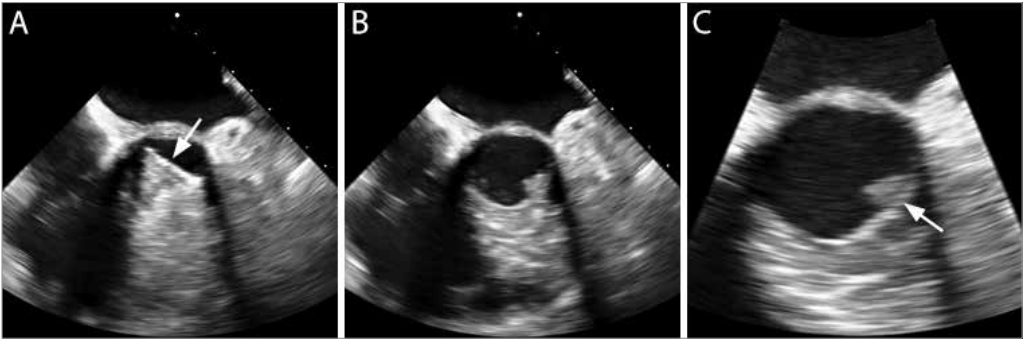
Transesophageal echocardiogram of the aortic prosthetic valve (posterior side of the valve displayed on top as seen through the oesophagus) of a patient suspected of prosthetic heart valve endocarditis. When the bi-leaflet prosthetic valve is opened during systole (A), the echo waves are deflected by the valve surface (arrow) resulting in a white streak artefact due to reverberation, which makes the anterior side of the valve and the annular tissue behind it uninterpretable. During diastole (B, C) – when the valve is closed – the anterior side of the valve can be depicted much better, and a small mass is identified just below the valve ring (arrow).
